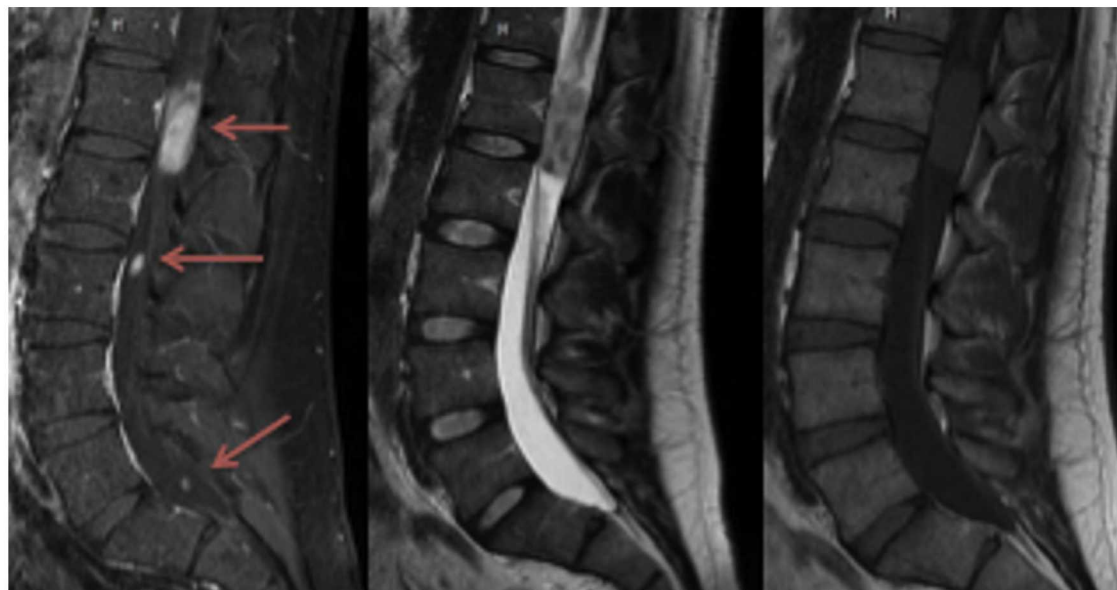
Magnetic resonance imaging studies: T1 with contrast (left), T2 without contrast (middle), and T1 without contrast (right). These images show 3 distinct, intradural, extramedullary lesions that enhance with contrast (red arrows).
